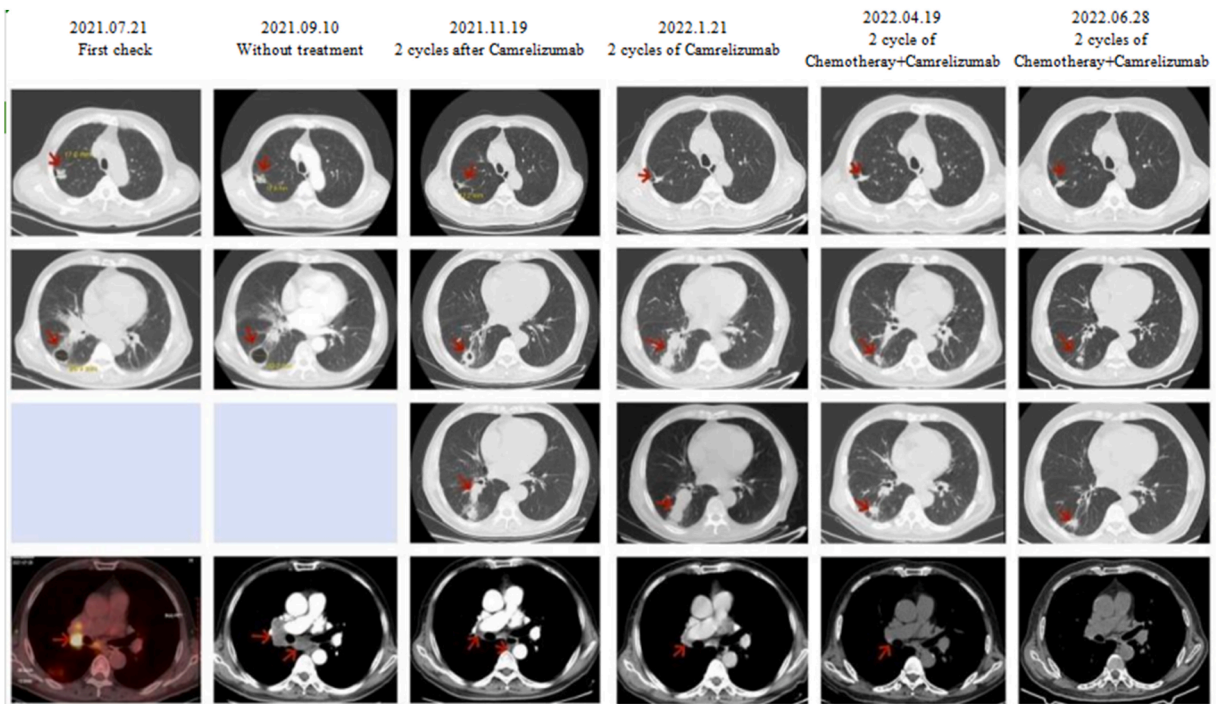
Computed tomography (CT) scan shows changes in primary lesions and mediastinal lymph nodes after camrelizumab and camrelizumab + chemotherapy.
